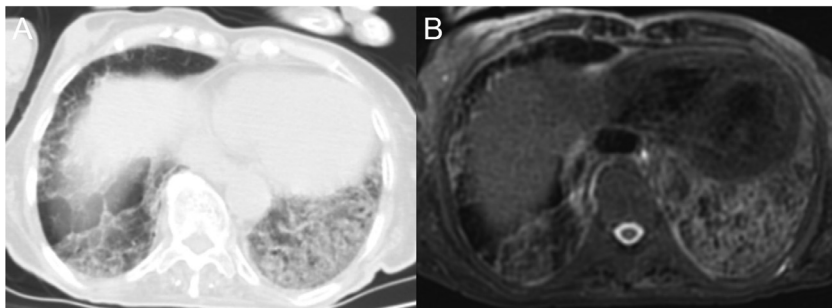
Crazy-paving pattern in an 81-year-old male patient. Interlobular and intralobular septal thickening and ground-glass appearance are displayed very successfully by MRI (b), as well as CT (a).
